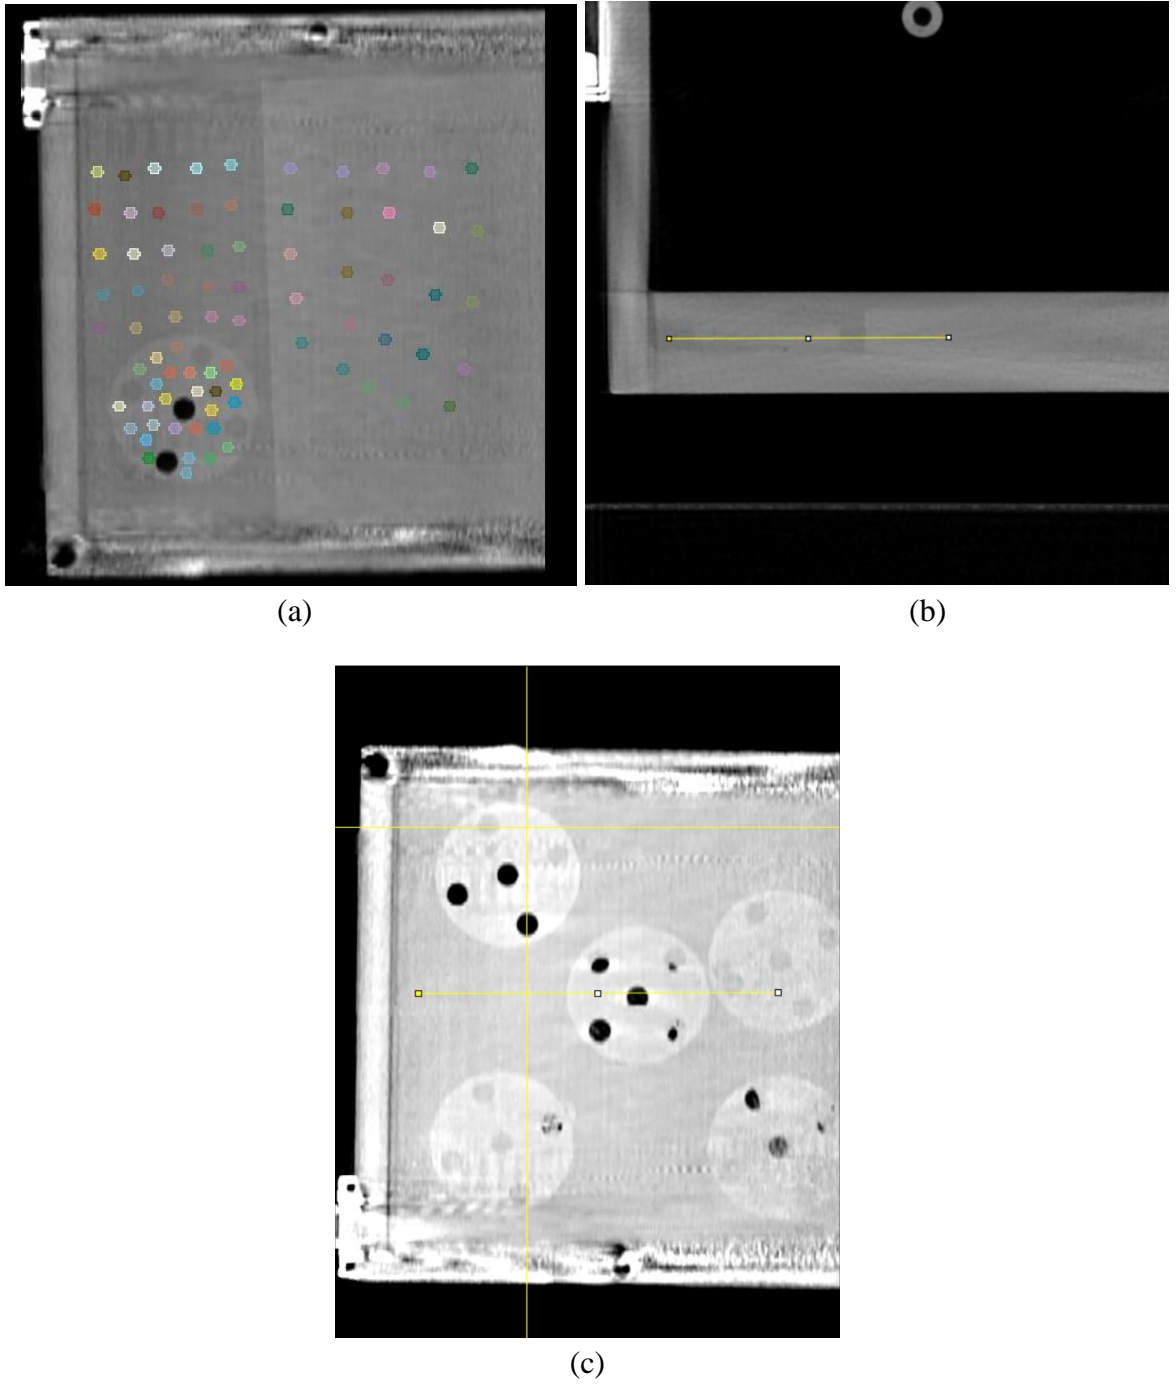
CBCT scan test for border artifacts evaluation
